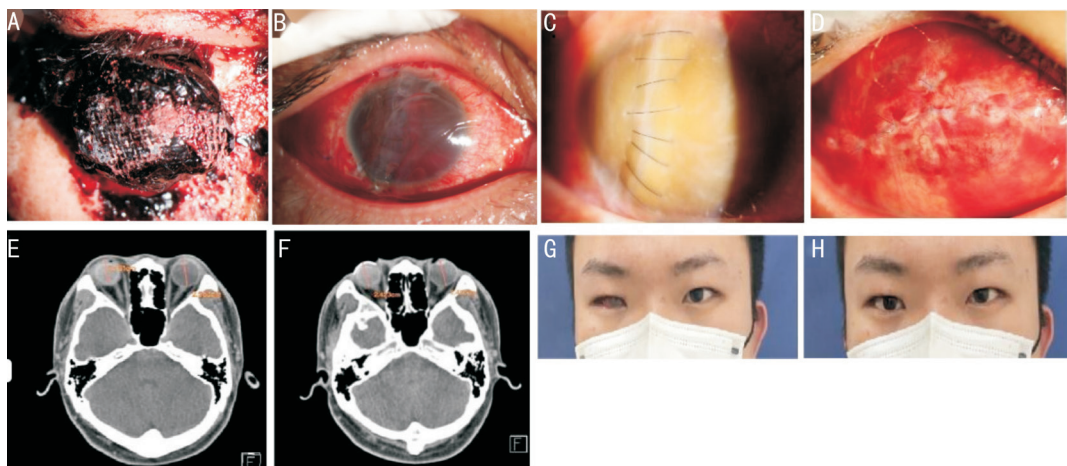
Vitreous cavity implanted into FCVB after severe ocular trauma in the right eye in December 2022 A, B: Anterior segment of the eye at the time of injury and after one-stage debridement suture in December 2022; C, E: Corneal clouding and atrophy with obvious corneal irritation at the time of the patient's re-examination in March 2023, with an axial length of the eye of 21.61 mm, a height of the lids of 6 mm; D, F, G, H: Anterior segment of the eye after conjunctival flap masking surgery and appearance after wearing the prosthetic eye piece, with the length of the eye axis 24.23 mm, the height of the lid fissure 8 mm, and the protruding degree of the eyeball 11 mm, and the orbital CT showed that the prosthetic eye piece fit tightly with the eyeball. FCVB: Foldable capsular vitreous body; CT: Computerized tomography.
